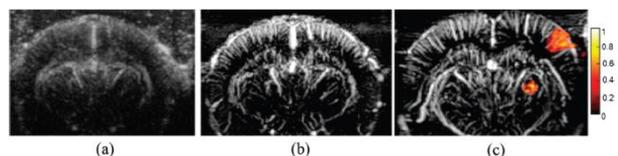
Functional ultrasound imaging during whisker stimulation a) Doppler, b) Ultrafast Doppler, c) brain activity (from ref [34])
